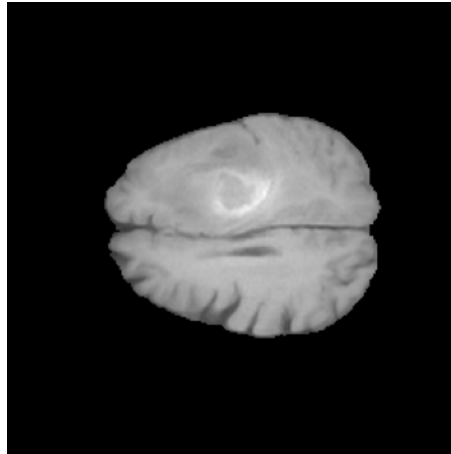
Example of T1-weighted MRI sequence.
